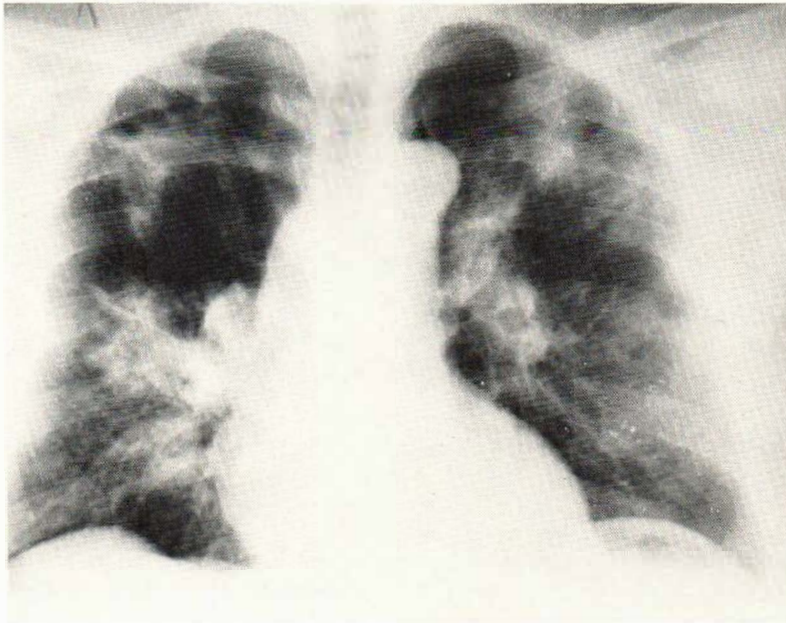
X-ray examination four months later shows marked progress of the granulomatous lesions in both upper lobes and in the region of the right hilum.
